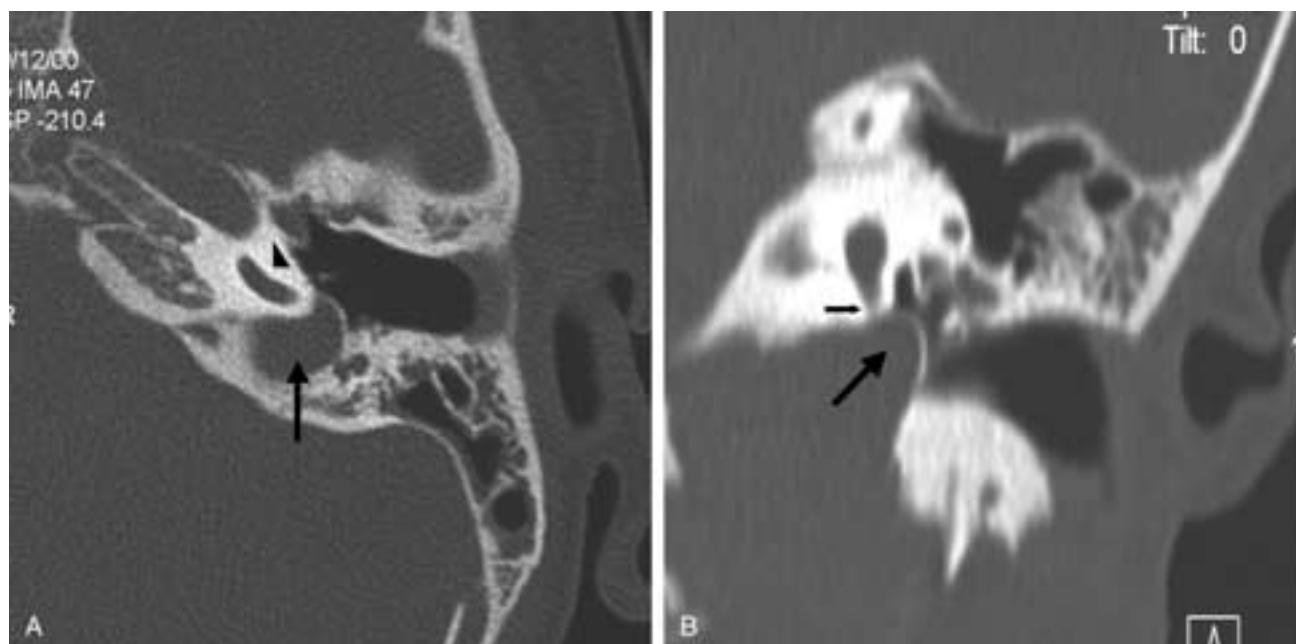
High-riding jugular bulb. A, Axial CT image showing the jugular bulb (*black arrow*) covering the basal turn of the cochlea (*black arrowhead*). B, Coronal CT image showing the jugular bulb (*large black arrow*) covering the round window (*small black arrow*).
